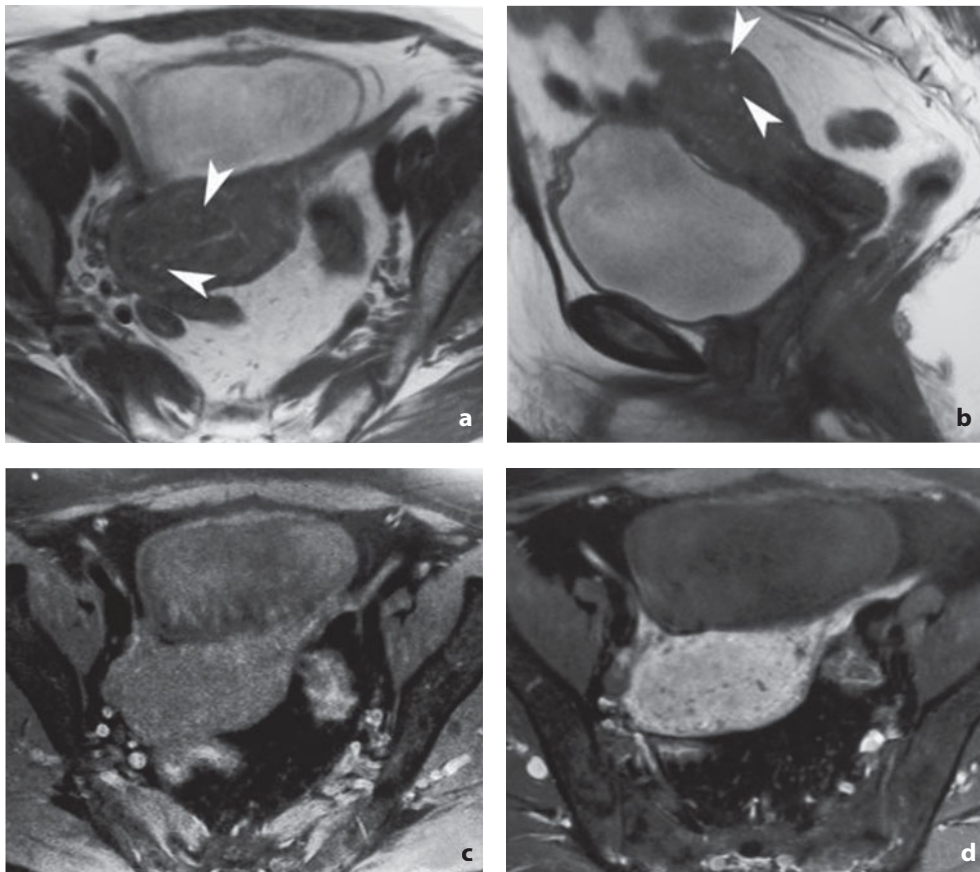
Magnetic resonance. Adenomyosis, diffuse form. Axial (a) and sagittal (b) T2-weighted images fail to identify the junctional line. Several hyperintense spots are visible within the myometrium and are referable to ectopic foci of endometrium (*arrowheads*). c,d Different case. In the axial fat saturated T1-weighted image before contrast medium injection (c) the hyperintense spots appear to be hemorrhagic foci. After contrast medium injection (d) the diffuse heterogeneity of the structure of the myometrium is confirmed
